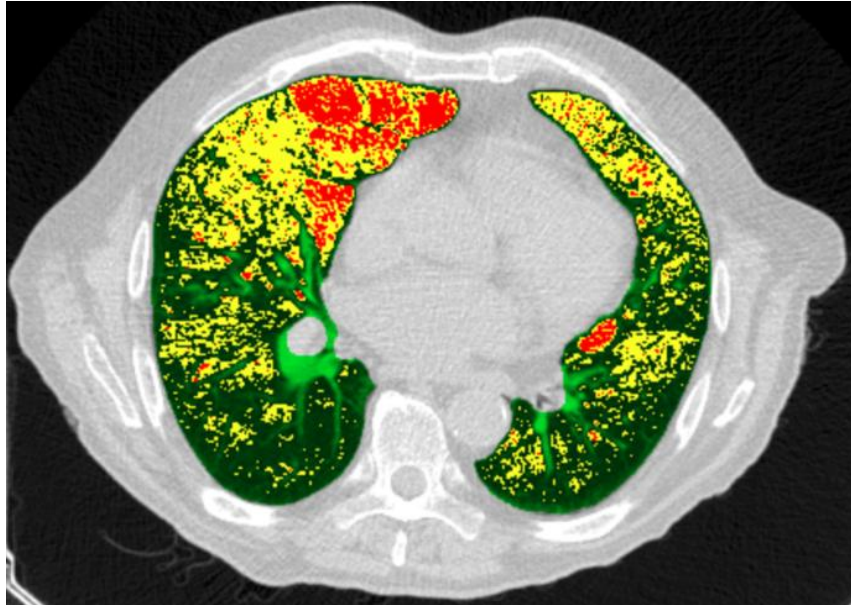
Density map on a lung cut from a CT scan on an emphysematous patient. Red regions have pathological low density, whereas green and yellow regions are in normal ranges. Data taken from [37].
